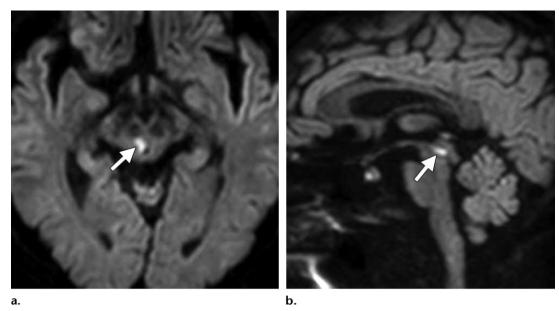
Vertical diplopia in a 67-year-old man. Axial (a) and sagittal (b) diffusion-weighted MR images show a small acute infarction (arrow) in the right posterior portion of the midbrain anterolateral to the cerebral aqueduct, a location that corresponds to the location of the right oculomotor nucleus.
